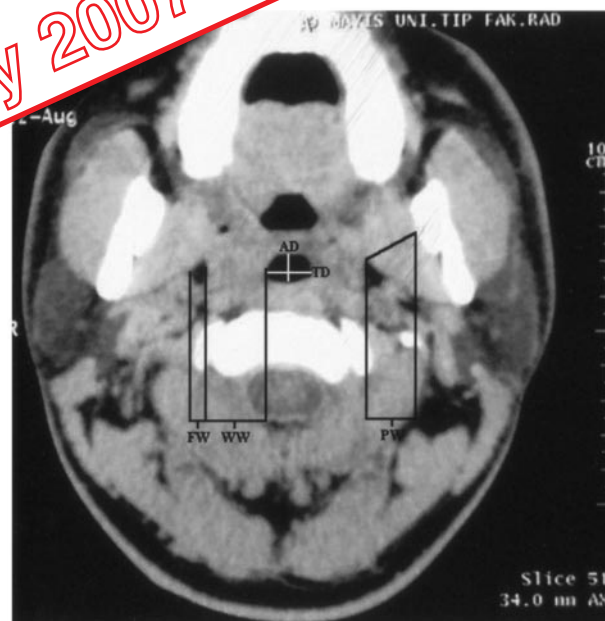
Axial CT image shows measurements at the oropharyngeal level. AD indicates anteroposterior airway diameter; FW, parapharyngeal fat pad width; PW, pterygoid muscle width; TD, transverse airway diameter; and WW, pharyngeal wall width.
